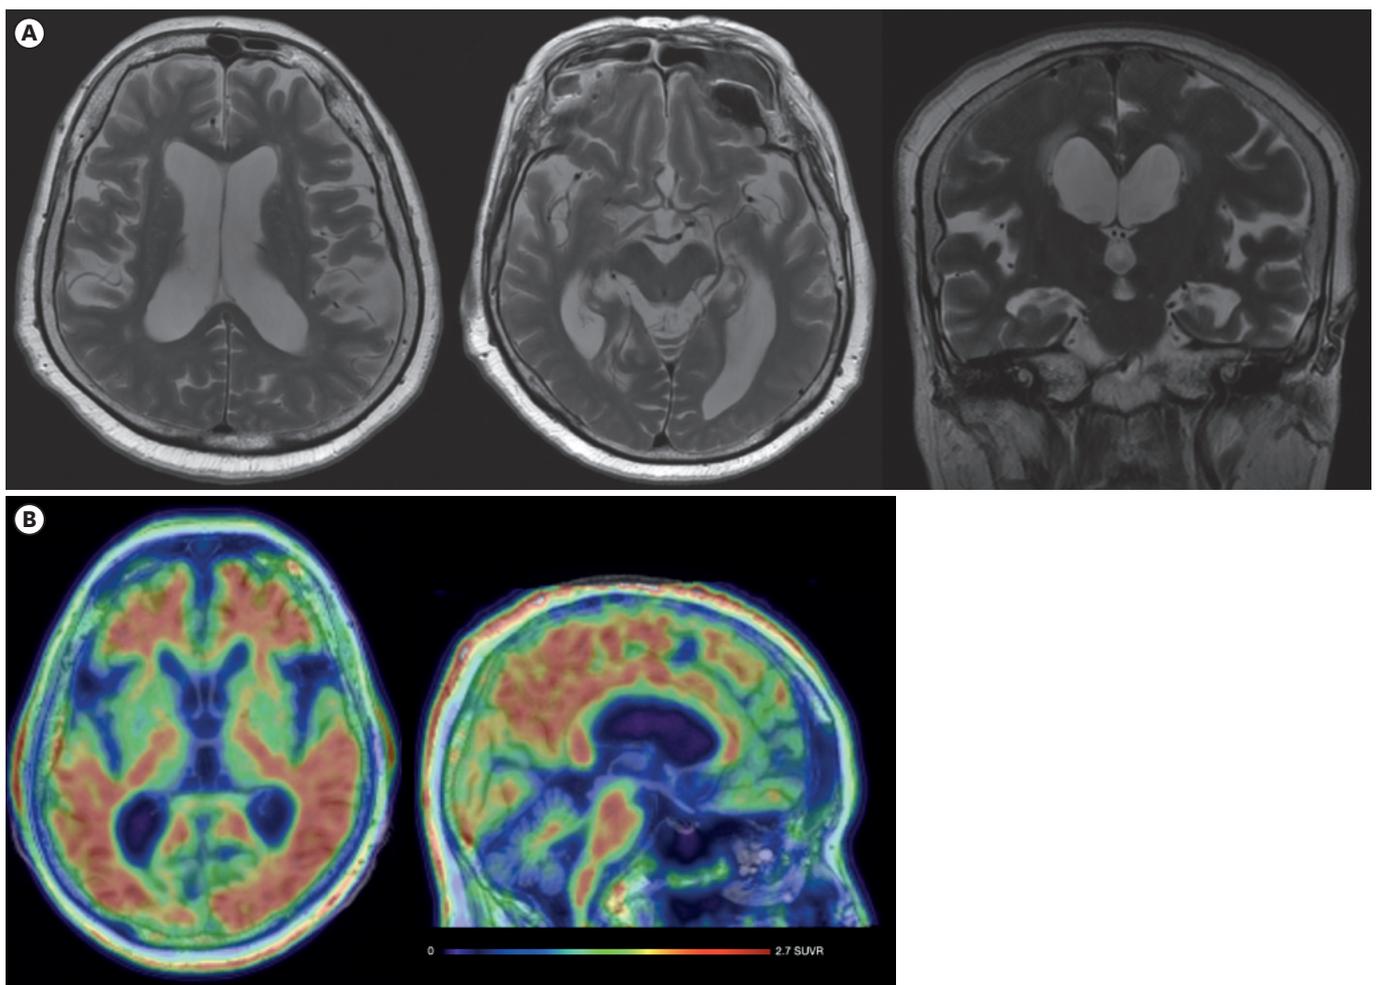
Preoperative brain magnetic resonance imaging. T2-weighted axial images show lateral ventricular enlargement with cerebrospinal fluid signal void in the cerebral aqueduct. Thinning of the corpus callosum with enlargement of the temporal horns of the lateral ventricles is also demonstrated in the T2-weighted coronal image (A). ¹⁸F-florbetaben positron emission tomography imaging shows a high tracer uptake in the frontal cortex, posterior cingulate gyrus, precuneus, and lateral temporal cortex (B).
